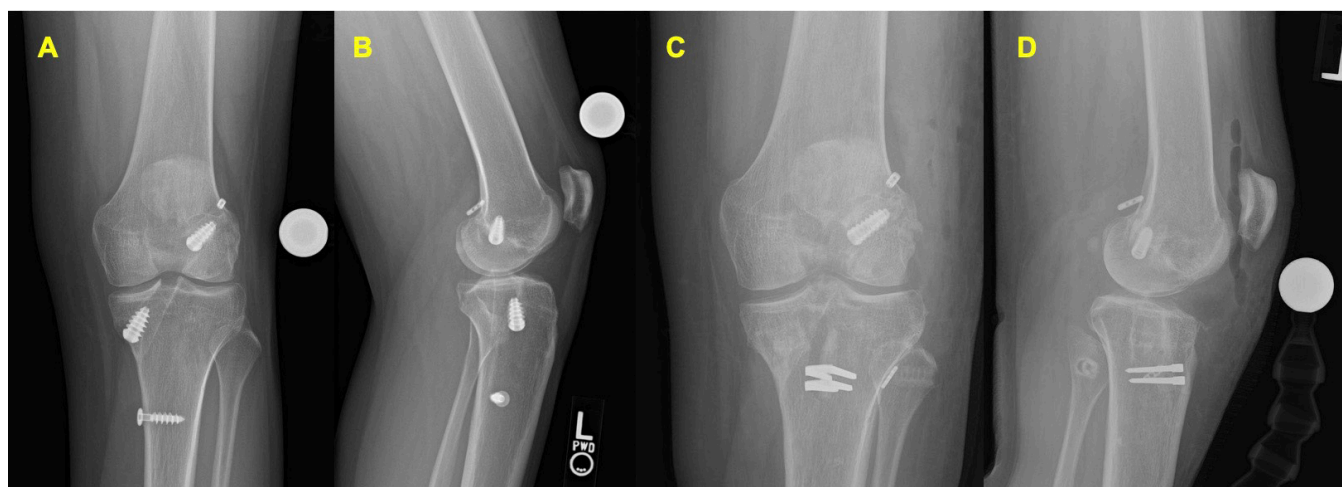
Pre-operative (A) anteroposterior (AP) and lateral (B) view radiographs of a left knee revision ACLR case with non-anatomic tunnels and poor hardware placement. Post-operative (C) AP and lateral (D) radiographs of the left knee after revision ACLR demonstrating anatomic tunnels and good hardware placement.
